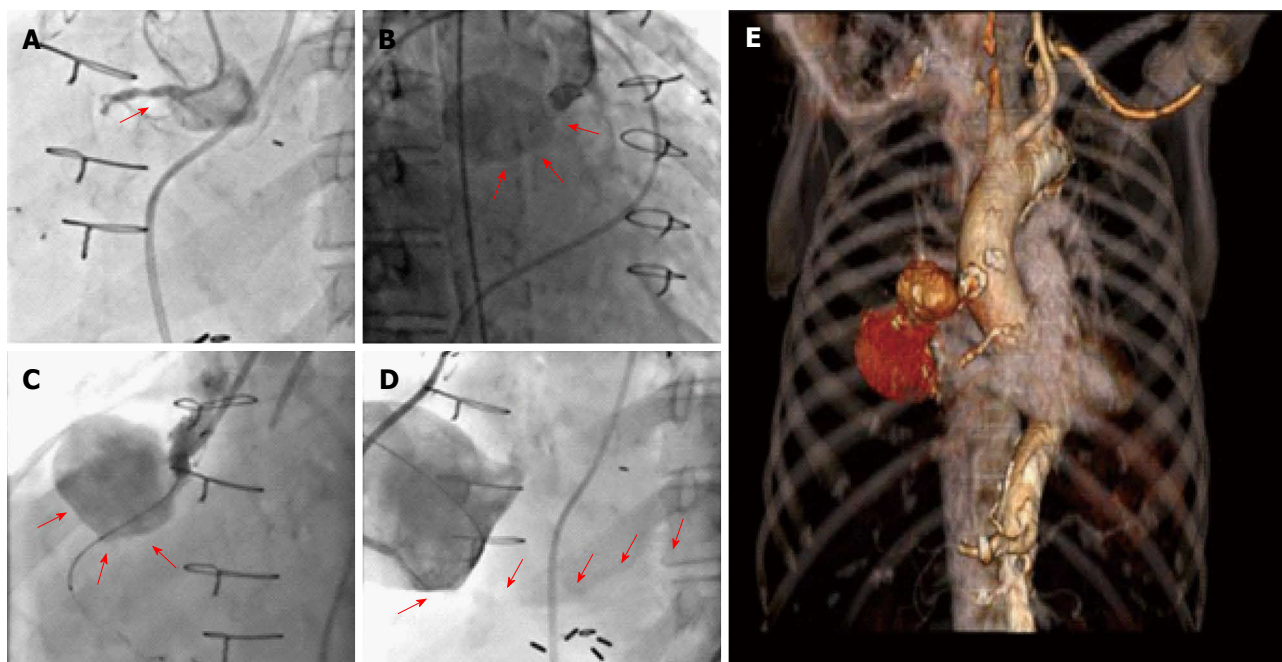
Coronary angiography demonstrated a giant pseudoaneurysm of the saphenous vein grafts with patent flow to the right posterior descending art. A: Coronary angiography showing the ostial and proximal right coronary artery (RCA) occlusion; B: Angiographic image depicting the upper lobe of the SVG to RPDA giant pseudoaneurysm; C: Giant pseudoaneurysm of vein graft with wide neck beginning about 2 cm from the graft origin; D: Injection within the aneurysm sac revealing a patent bypass graft that continues into the distal right coronary artery with a sequential connection to the posterior descending artery; E: Computed tomographic 3-D reconstruction of the SVG giant bilobed pseudoaneurysm to the distal right coronary artery seen in relation to the thoracic structures. SVG: Saphenous vein grafts; RPDA: Right posterior descending artery.
